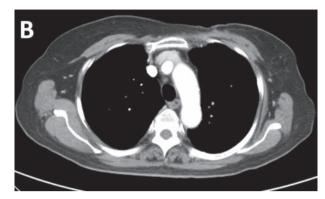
(A) Contrast-enhanced computed tomography of the thorax shows an outsize left-breast cancer with major pectoris muscle invasion and multiple nodal metastases. (B) After neoadjuvant chemotherapy, anti-HER2 target therapy, and local surgical debridement, significant disease regression was seen in the left-breast tumor and lymph node metastasis
